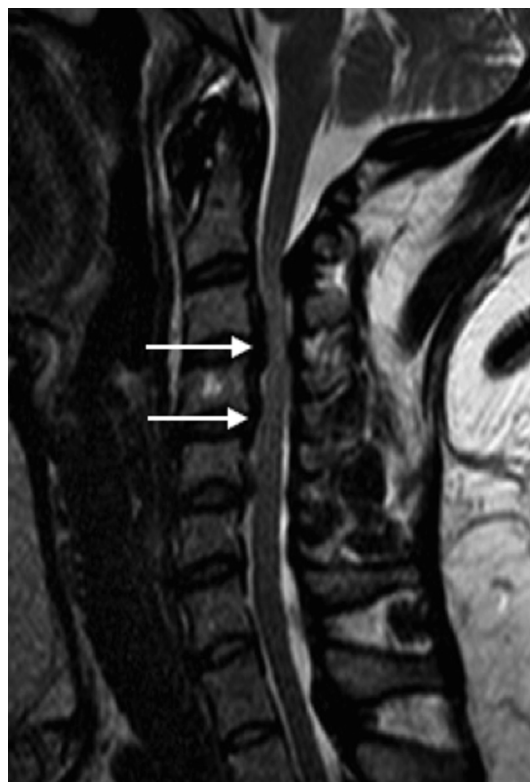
Sagittal T2-weighted magnetic resonance images of the cervical spine on presentation demonstrating hypertrophy of the posterior longitudinal ligament at C3–C4 and C4–C5 (arrows), with resultant cervical stenosis at C3–C4 and mild stenosis at C4–C5 and C5–C6.
